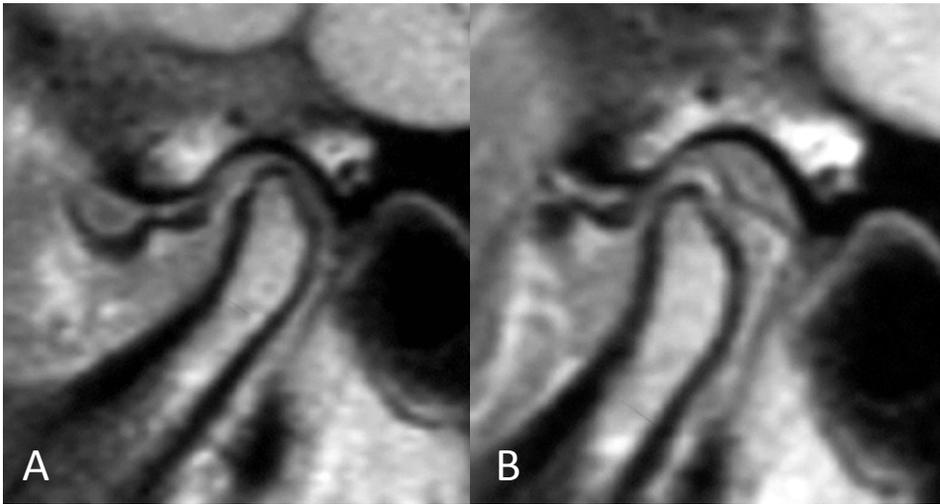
MR images of Anteriorly Displaced Discs without Reduction (ADDwoR).
